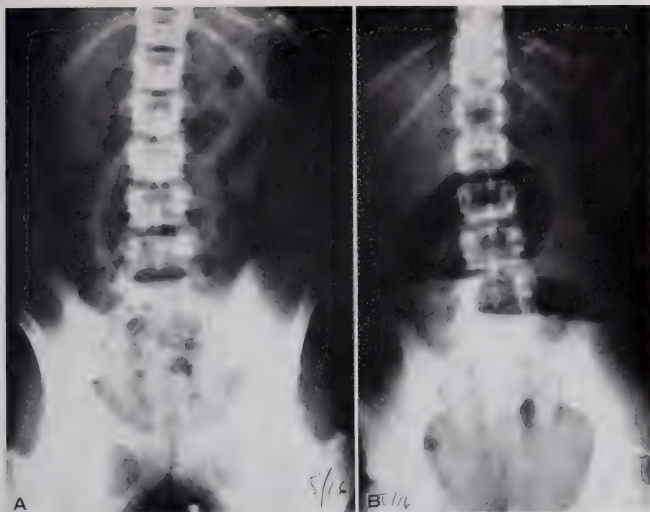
Abdominal x-rays taken in the supine and upright positions show evidence of small bowel obstruction.
